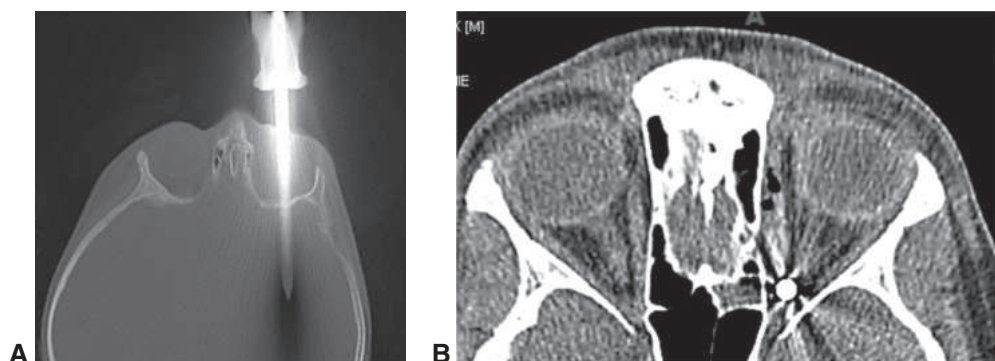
Intraorbital foreign body. A, Coronal CT image demonstrates a screwdriver entering the superior orbit and passing into the anterior cranial fossa. Removal required multidisciplinary approach with neurosurgery. B, Coronal CT image shows metallic, apical foreign body of the left orbit consistent with a BB from a BB gun. These foreign bodies can be observed without consequence as surgery to retrieve them can be dangerous. (Courtesy of Steven M. Couch, MD.)
